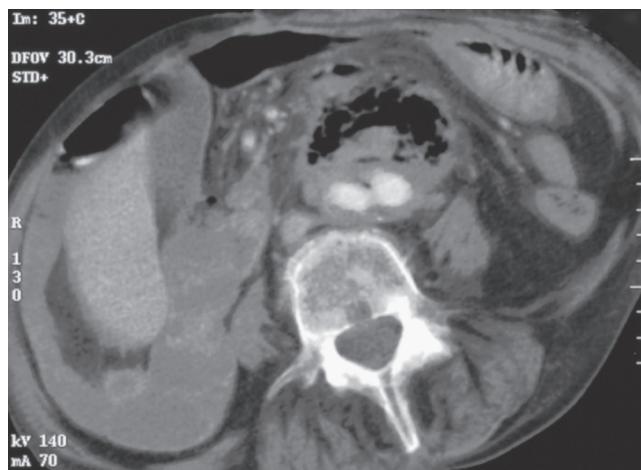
Contrast-enhanced computed tomography scan of a patient with a secondary aortoenteric fistula. Note the accumulation of gas and retroperitoneal inflammation surrounding a bifurcated aortic prosthesis.
